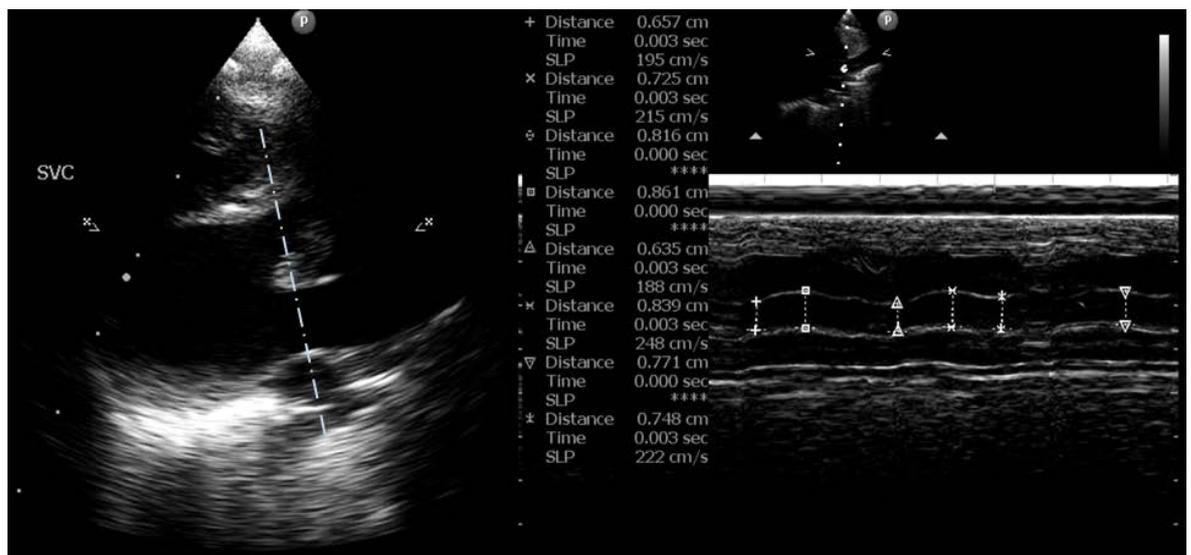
Echocardiographic measurement of SVC diameter via M-mode
